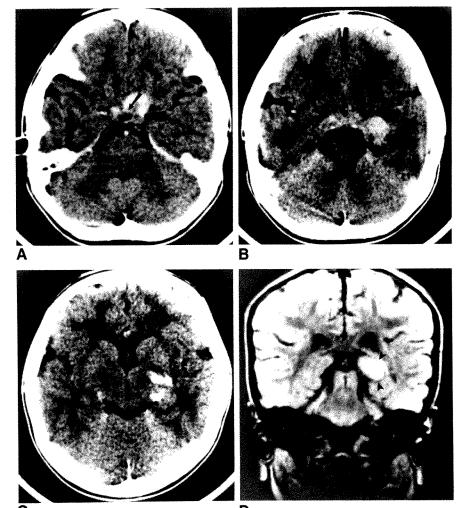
A-C, Contrast-enhanced axial CT scans show chiasmal pilocytic astrocytoma with bilateral postchiasmal optic pathway extension. Noted are tumor calcifications in left optic tract and microcyst in chiasmal tumor (arrow). Right optic tract is minimally involved, and there is uncertainty about left lateral geniculate body involvement.
